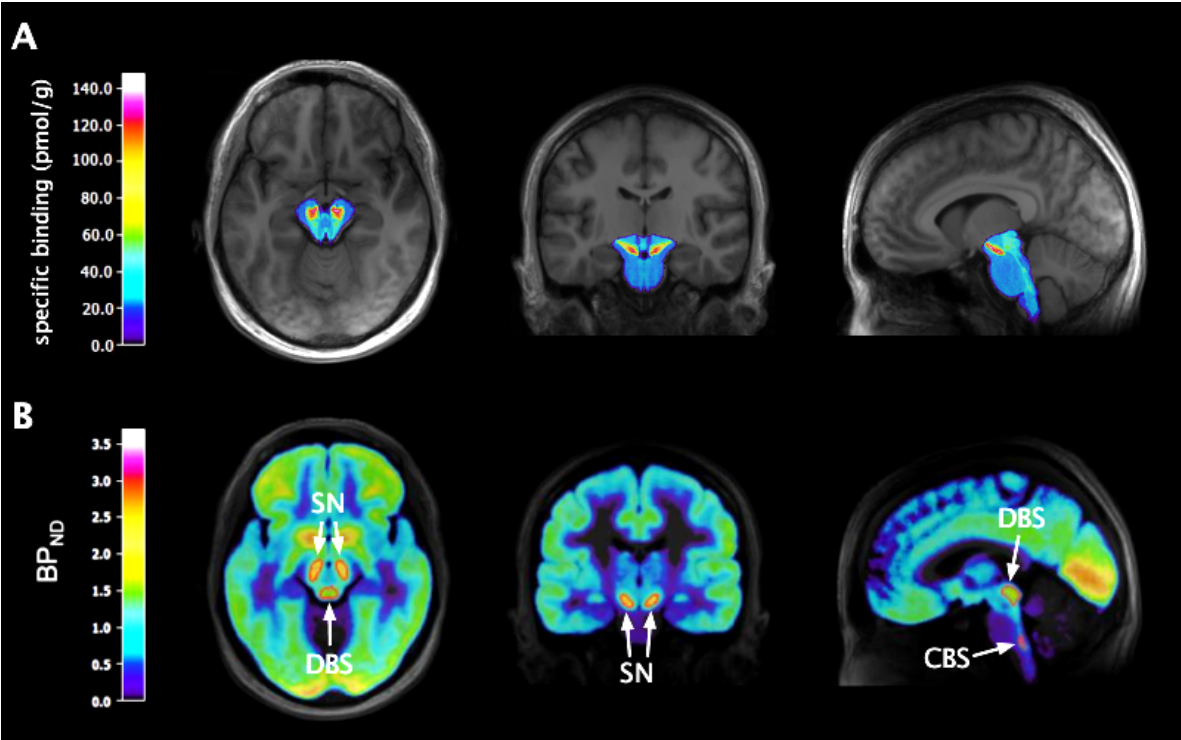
A) 3D model of [^3H]AZ10419369 ARG specific binding. B) Template [^{11}C]AZ10419369 PET data with in red the Volumes of Interest DBS (dorsal brainstem), CBS (caudal brainstem) and SN (substantia nigra). Both modalities are overlaid on template MRI data
